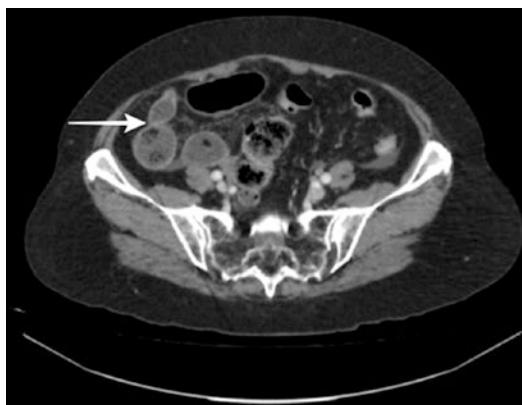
CT imaging of a transition point in the right lower quadrant (white arrow)
